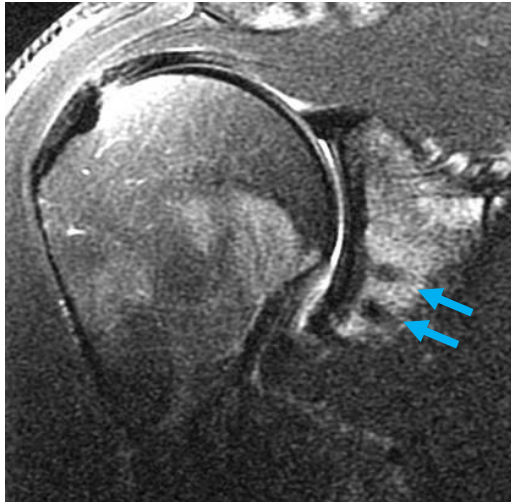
MRI of Patient A shows no drill tunnel widening or cyst formation.
